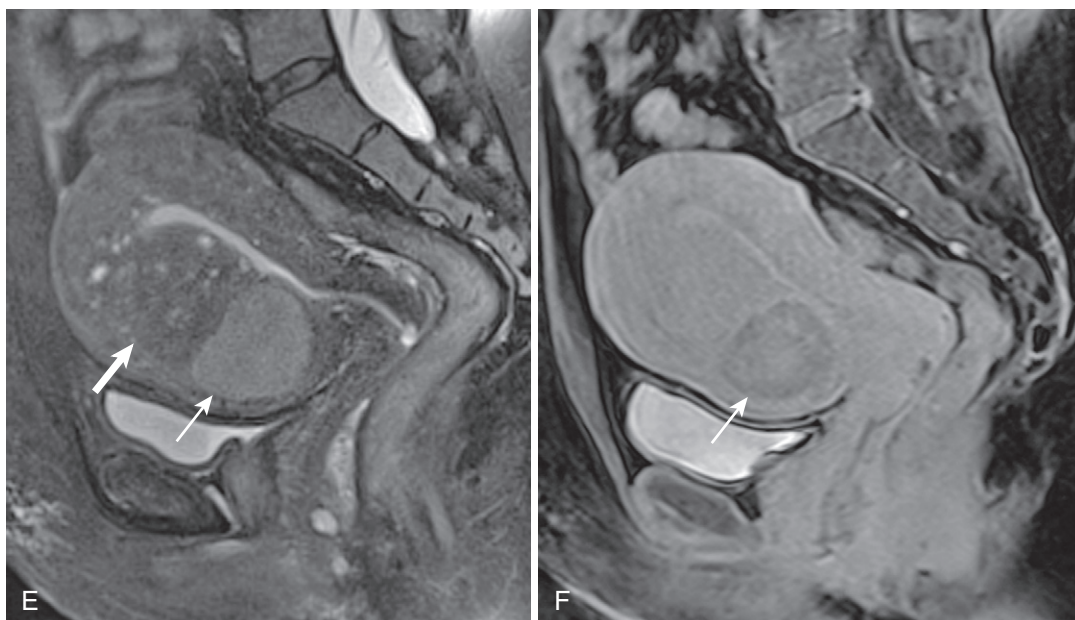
cont'd E and F, In a different patient, an intramural fibroid undergoing myxoid degeneration in the anterior lower uterine segment (*thin arrow* in E) demonstrates much greater T2 hyperintensity than the adjacent adenomyoma (*thick arrow* in E) on the sagittal T2-weighted fat-suppressed image (E) and minimal enhancement (*arrow* in F).
